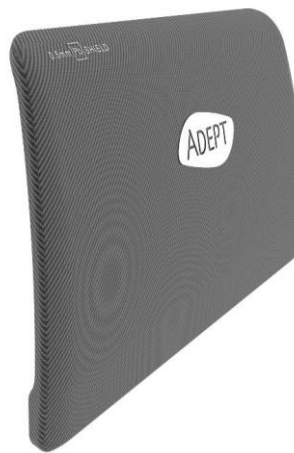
Adept Medical X-Ray Shield
